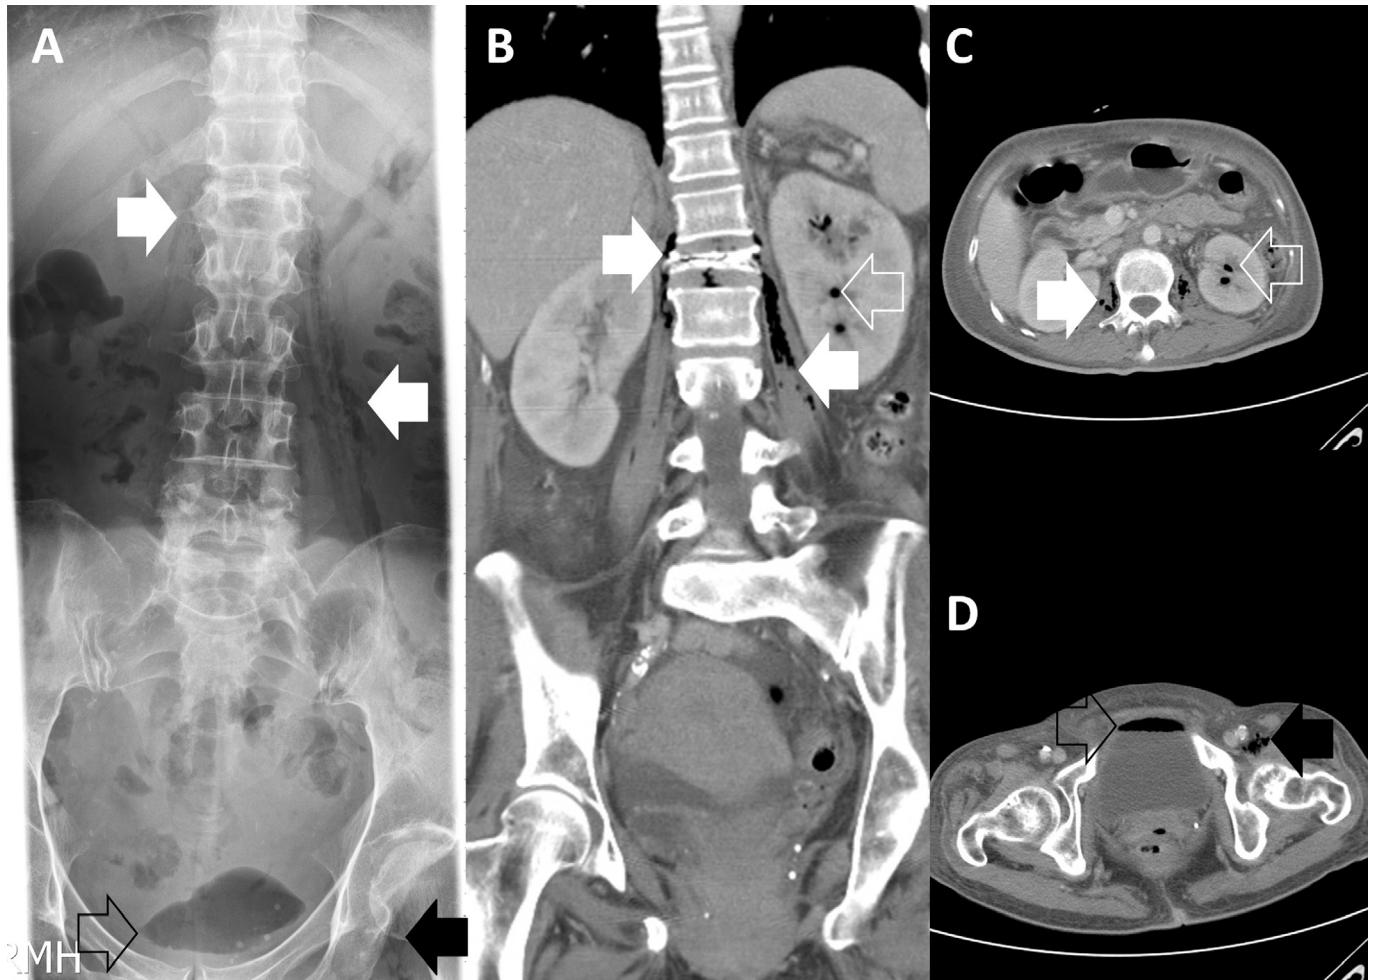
Anteroposterior view of the lumbar spine showing compression of the first lumbar spine, radiolucency along the bilateral psoas muscles (white arrows in A) suggestive of bilateral emphysematous iliopsoas abscess with extension to the left hip joint (black arrow in A), and air within the bladder (hollow black arrow in A) suggestive of emphysematous cystitis. The axial and coronal contrast-enhanced abdominal computed tomography (CT) scan views revealed compression of the first lumbar spine with air bubbles within the spine and spinal canal (pneumorrhachis), bilateral emphysematous iliopsoas abscess (white arrows in B and C) with extension to the left hip joint (black arrow in D), left emphysematous pyelonephritis (hollow white arrows in B and C), and emphysematous cystitis (hollow black arrow in D).
